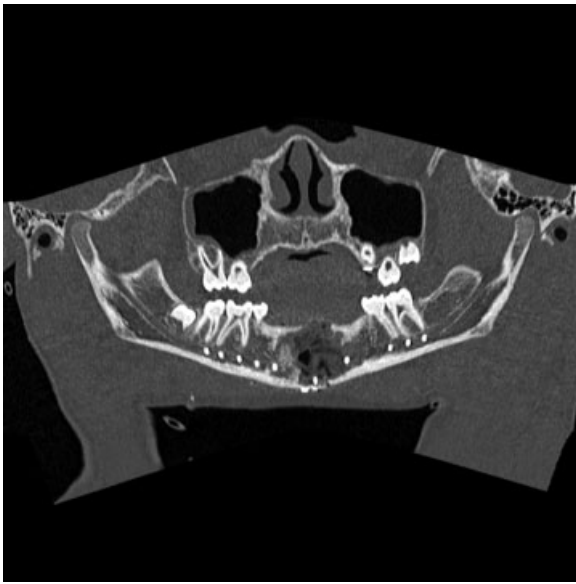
Panorex computed tomography scan obtained in the immediate postoperative period showing improved anatomic alignment.
